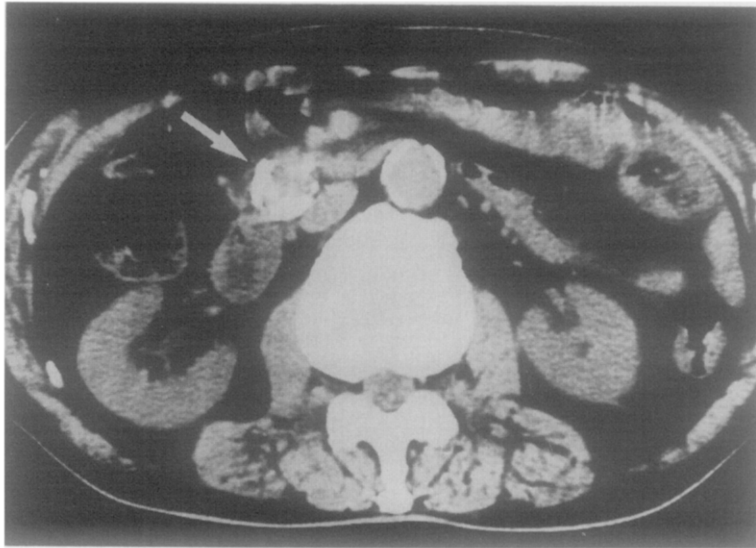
Computed tomography scan shows calcified lesion beneath pancreas head (*arrow*) and marked calcification of abdominal aorta.
